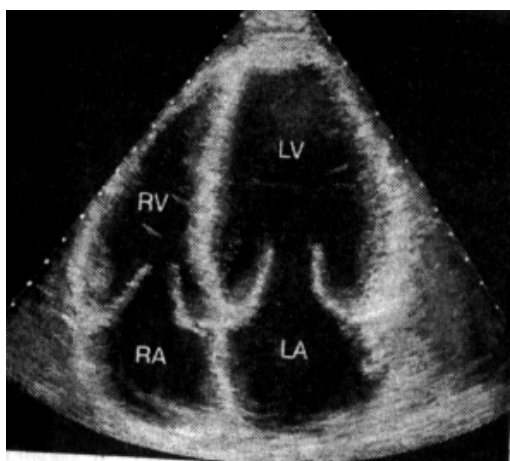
The scheme of ultrasonic scanning in apex positions. Ultrasound examination (B-mode). Research from apex position. The note: septum interventricular and septum interatrial partitions settle down in the centre. To the left of them right ventricle (RV) and the right atrium (RA) are visualised and on the right – left ventricle (LV) and left atrium (LA). In this position leaflets mitral and tricuspid valves are well visualised also [72]
